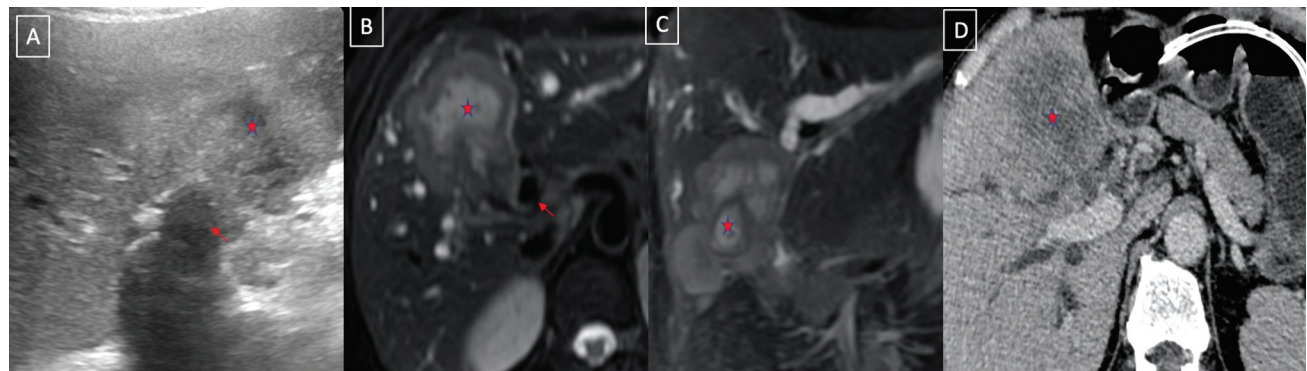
Mass-forming type of gallbladder cancer. Grayscale ultrasound (A), axial (B) and coronal (C) T2-weighted magnetic resonance imaging, and axial computed tomography (D) images showing the mass-forming type of gallbladder cancer (asterisk) replacing the normal gallbladder, infiltrating into the adjacent liver and biliary radicles.
